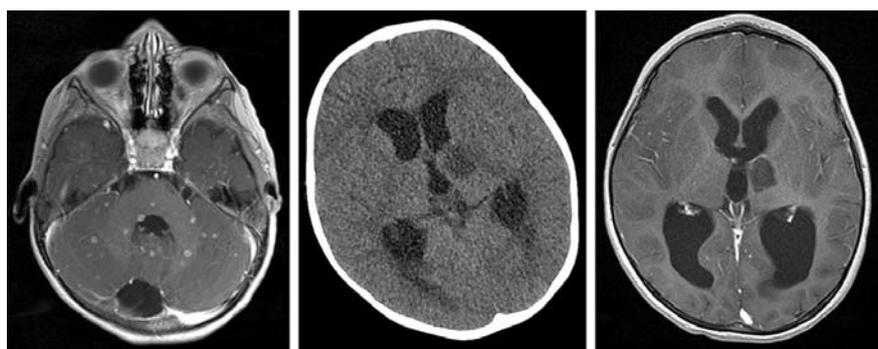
Left Panel) multiple contrast-enhanced nodular lesions of the whole encephalus on T1 sequence cerebral magnetic resonance imaging (MRI). Central Panel) Cerebral computed tomography-scan demonstrating enhancing hydrocephalus and hypodense lesion of left thalamic region two days later. Right Panel) Evolution after 7 weeks of anti-tuberculous and steroids therapy: disappearance of nodular lesions, persistence of hydrocephalus and thalamic ischemic lesion on T1-weighted + gadolinium MRI.
